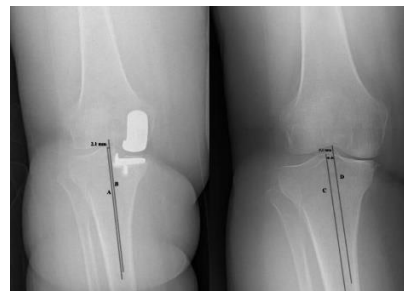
Radiograph demonstrating measurement of the tibiofemoral subluxation.
